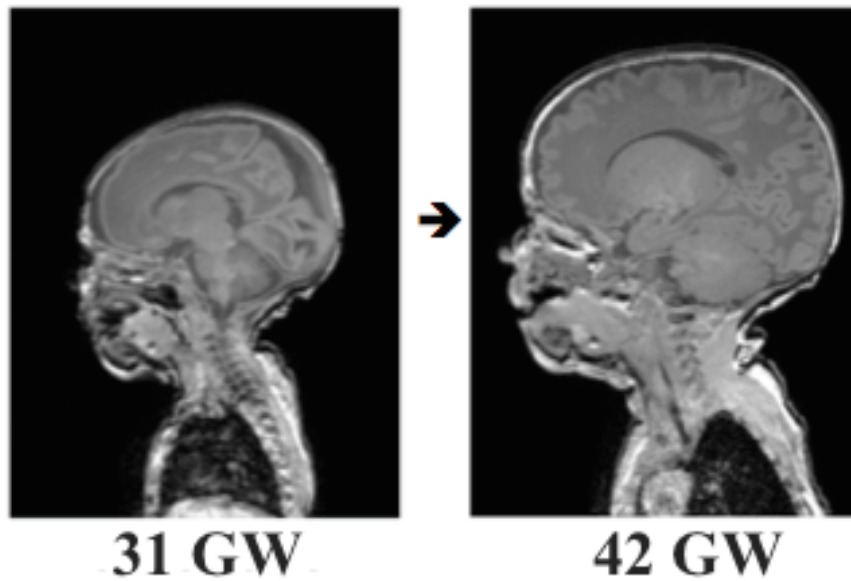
Example of a T1-weighted MRI of an extremely preterm born infant, scanned twice: once shortly after birth and once around term time.
